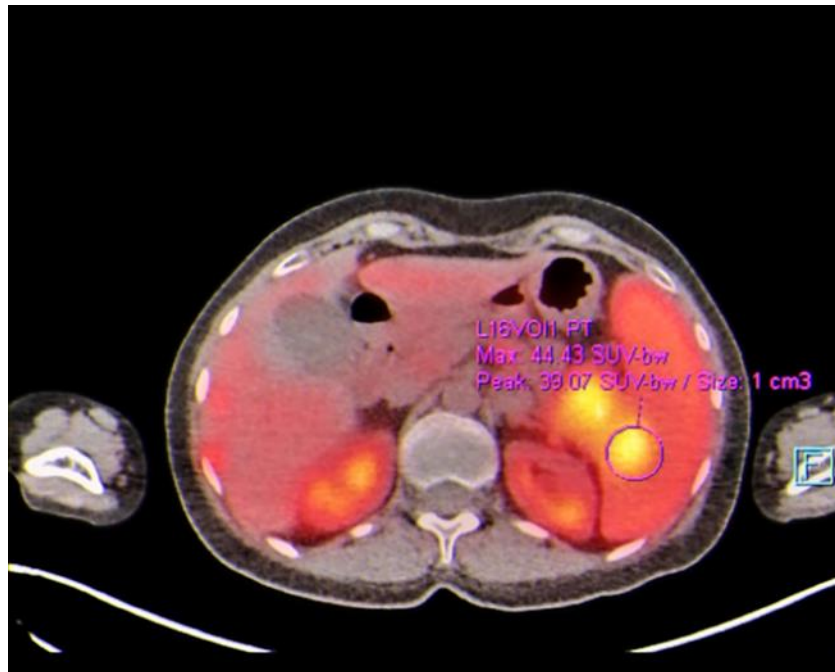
The image represents a follow-up Pet scan after 6 cycles of chemotherapy showing a less prominent appearance of the previously mentioned large splenic lesion, currently measuring about 2.1 cm on fused images with SUV max=44.43 compared to 3.63 x 3.5 cm & SUV max 80 previously. Moreover, it emphasizes a less prominent appearance of the previously mentioned large soft tissue mass lesion within the tail of pancreas, currently is measuring about 3.7x2.7cm in maximum axial dimensions with SUV max=44.3 compared to 4.67x2.7 cm & SUV max 81 previously
